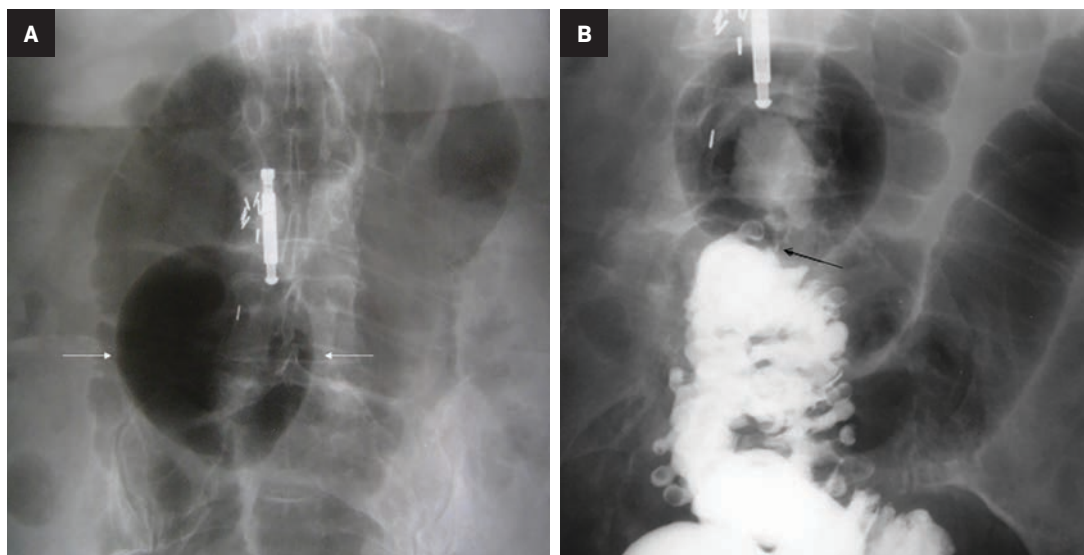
Radiological appearance of a GSD in an elderly adult. (A) Abdominal film demonstrates 6 cm, oval-shaped gas collection. (B) Iodinated contrast enema shows partial opacification from its connection to the sigmoid (arrow). (C) CT examination 9 months later reveals slight enlargement of this GSD and thickening of its wall (arrows). This patient underwent laparoscopic resection of the sigmoid colon.
